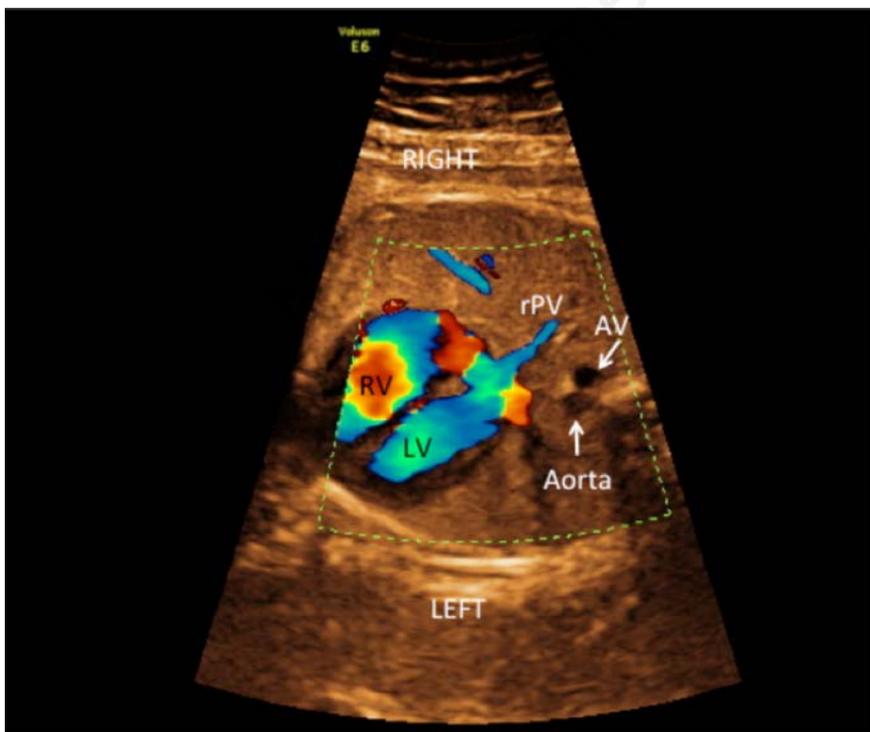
Fetal echocardiography performed at 35 weeks of gestation. The vena azygos (AV) is positioned on the right side of the aorta (Ao). Intracardiac structures are normal. rPV, right pulmonary vein; LV, left ventricle; RV, right ventricle.
